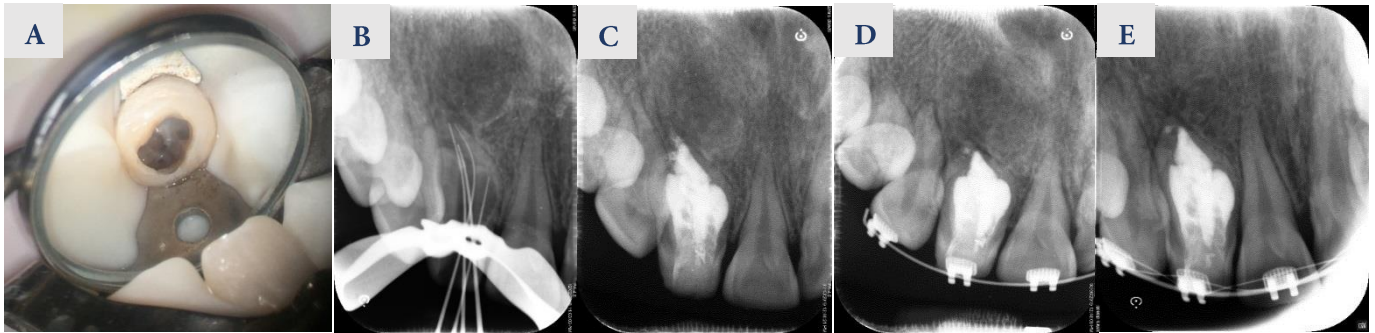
Intraoperative and immediate postoperative images, A) Prepared access cavity, note that four portions are detectable on tooth #7; B) Working length determination; C) Post-operative radiograph; D) Radiographic evaluation at six months follow-up showed continued improvement of periapical lesion; E) In one year follow up, resolution of the periapical radiolucency can be seen
